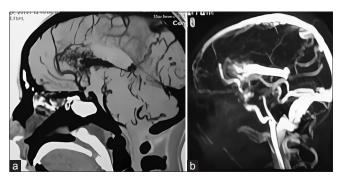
Pre-operative (a) computed tomography angiography with early venous phase and (b) magnetic resonance venography (sagittal views) showing spetzler-Martin Grade 4 arteriovenous malformations of the corpus callosum, located at genus and rostrum of corpus callosum, with extension into the third ventricle. The feeders are visualized coming from the anterior pericallosal artery and a very large deep draining vein terminating at the vein of Gallen is seen.
